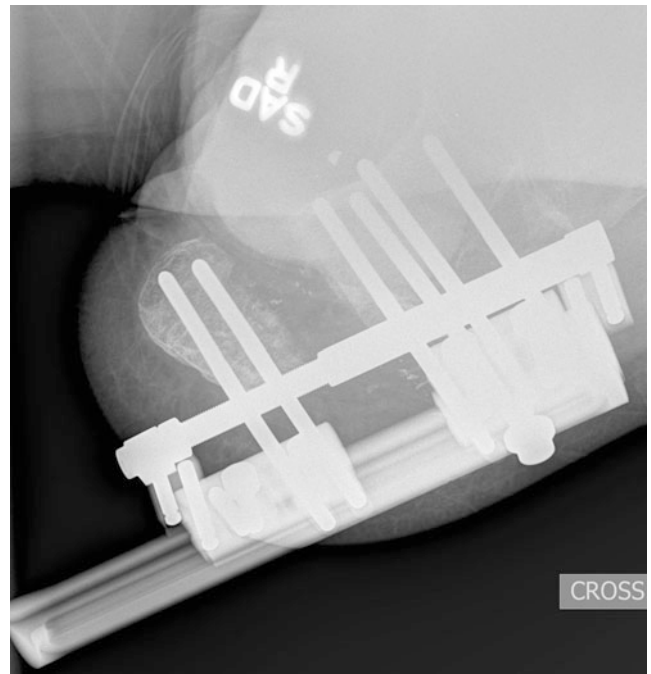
Lateral X-ray of the right femur during lengthening phase
